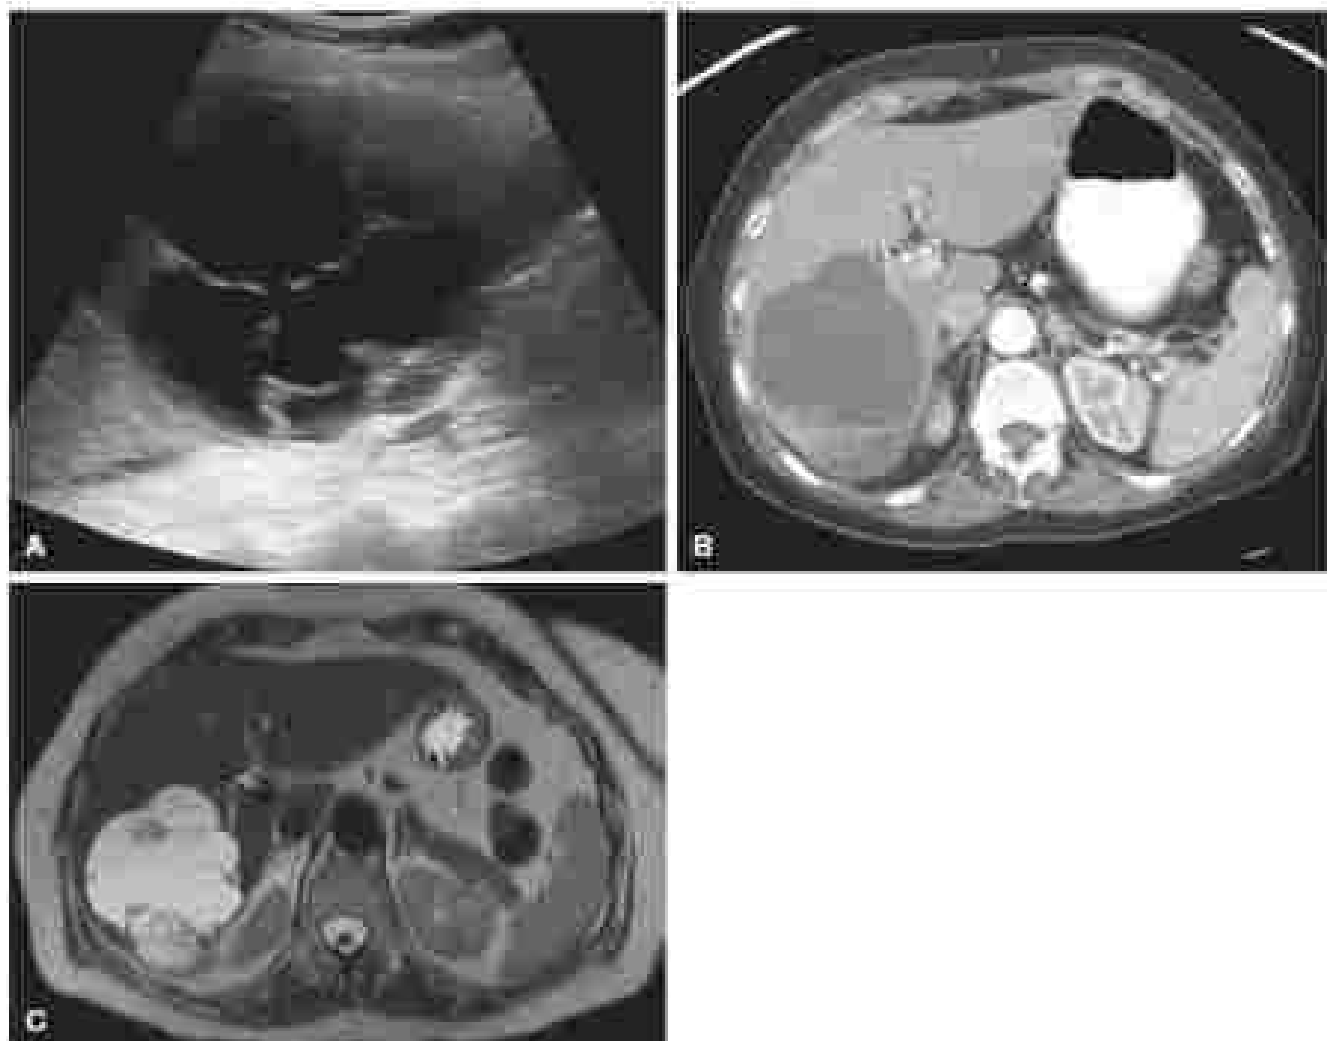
Ultrasound (A) image findings consistent with complex cyst typical for cystadenoma (noting internal septations and mural nodule) and papillary projections and lobes. Corresponding contrast angiography (B) and magnetic resonance (C) images demonstrating anastomotic structural complexity.
